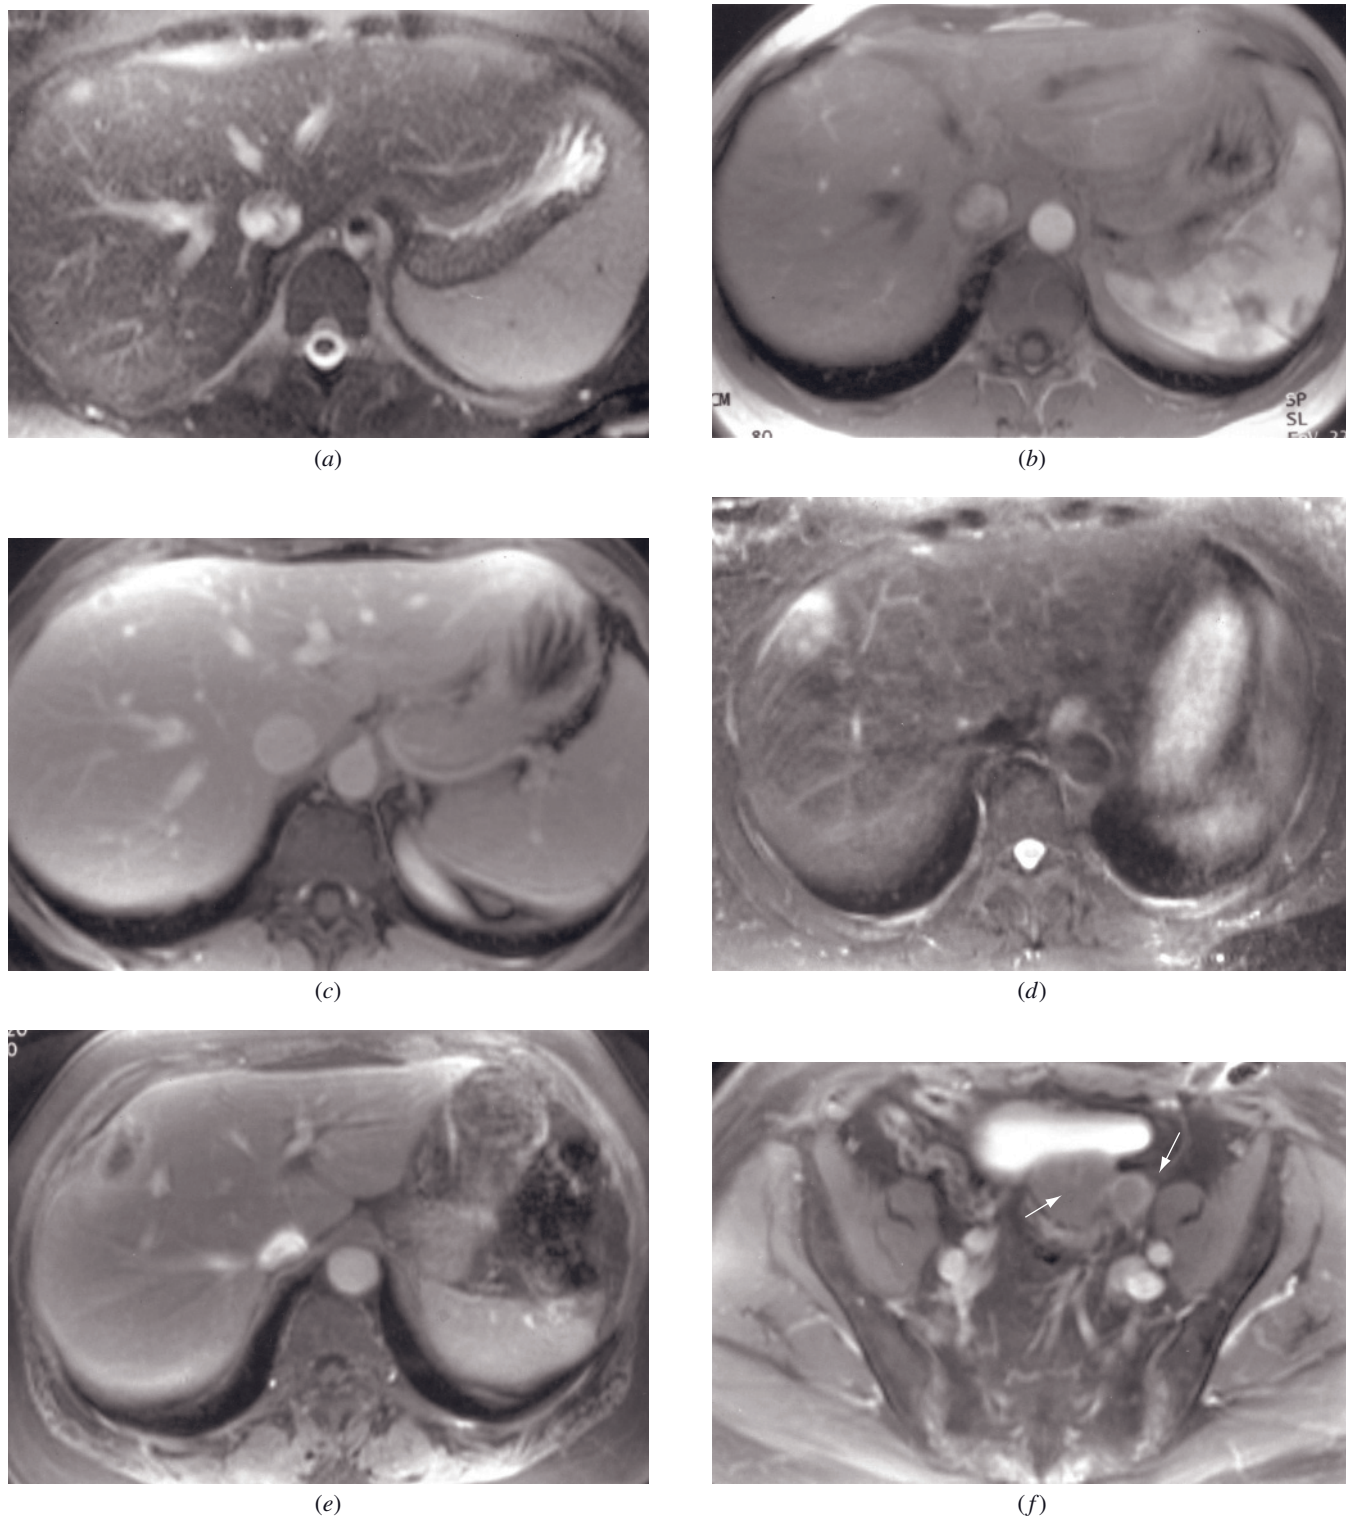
Liver and peritoneal metastases from ovarian tumor. Echo-train STIR (*a*) and immediate (*b*) and 90-s fat-suppressed (*c*) postgadolinium SGE images in one patient and echo-train STIR (*d*) and 90-s fat-suppressed postgadolinium SGE (*e*, *f*) images in a second patient, both of whom have ovarian cancer and peritoneal metastases. Both patients demonstrate liver metastases characterized by high signal on T2-weighted images (*a*, *d*) and ring enhancement on early (*b*) and late (*c*, *e*) postgadolinium images. Note the presence of recurrent pelvic tumor (arrows, *f*) in the second patient.
